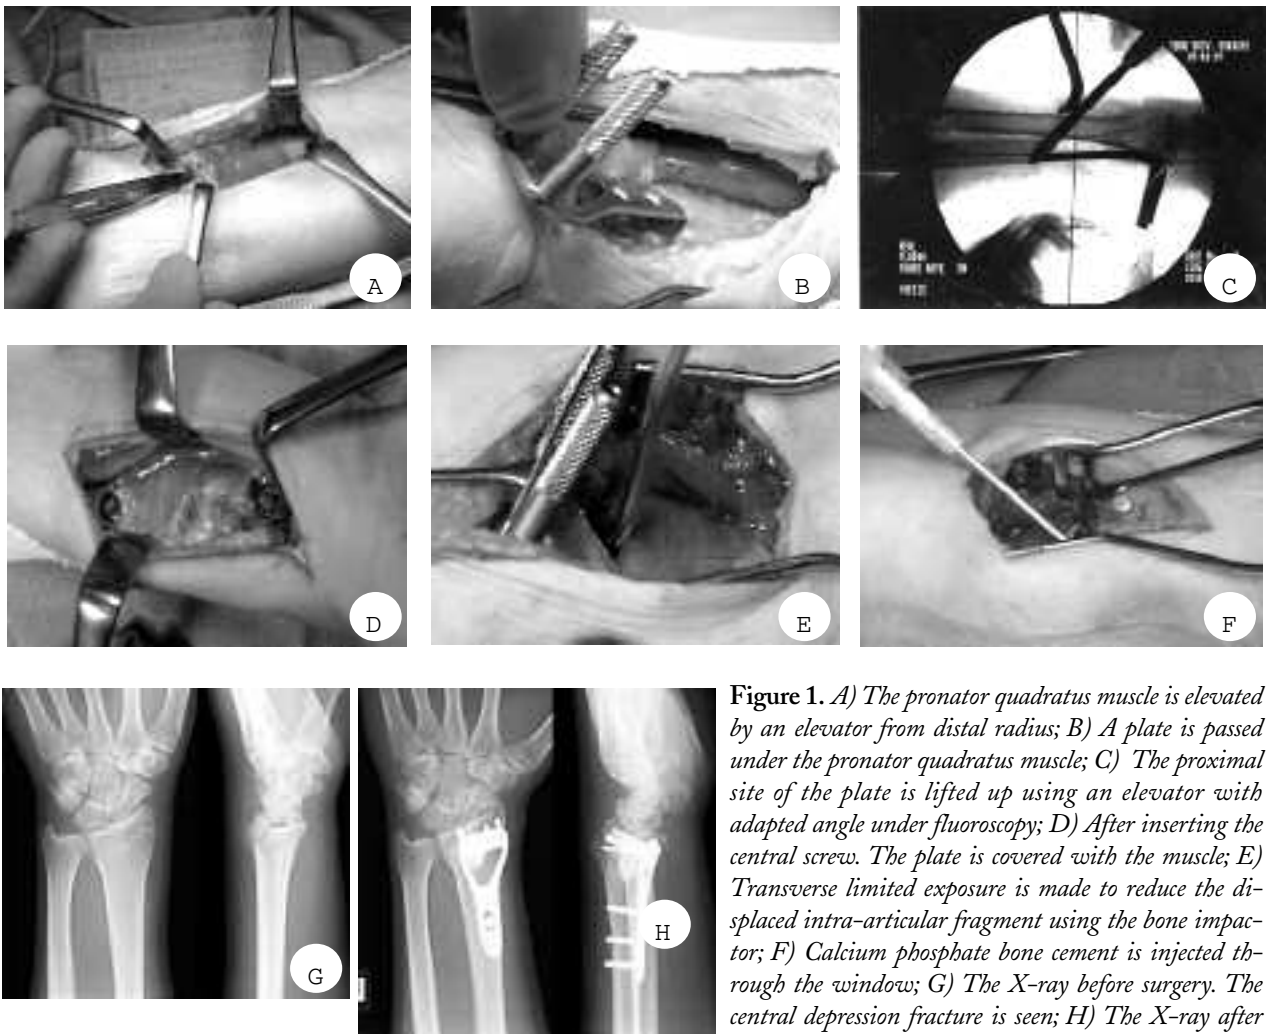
A) The pronator quadratus muscle is elevated by an elevator from distal radius; B) A plate is passed under the pronator quadratus muscle; C) The proximal site of the plate is lifted up using an elevator with adapted angle under fluoroscopy; D) After inserting the central screw. The plate is covered with the muscle; E) Transverse limited exposure is made to reduce the displaced intra-articular fragment using the bone impactor; F) Calcium phosphate bone cement is injected through the window; G) The X-ray before surgery. The central depression fracture is seen; H) The X-ray after surgery. Anatomical reduction is achieved.*
